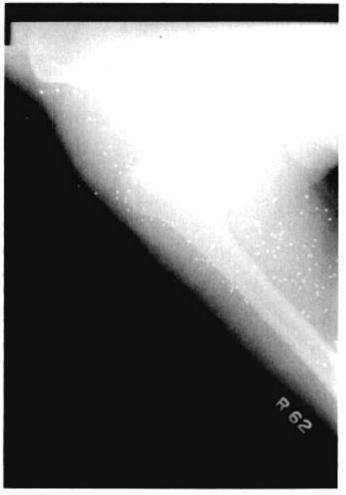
Full load of No. 6 shot in right thigh. Using the formula provided the effective range for this wound was 12 meters. This would be 12 meters for a standard length shotgun or much closer for a "sawedoff" shotgun. This would make this wound a Type II, with a moderate amount of tissue damage and mortality rate of approximately 15–20%. The actual length of barrel used is not important as the effective range is known in this case. The effective range may be calculated in three ways for this wound. First, the full load produced a wound with a diameter of 14 inches which may also be measured by the pellet spread on X-ray. Assuming a spread of approximately 1 inch per meter from 2 to 100 meters range, this would indicate that the weapon-victim range was approximately 12 meters. Second, the effective range can be calculated after measuring the distance between pellets. The shot size is measured at .11 inches in diameter which is #6 shot (see Table II) and each 1½-ounce load would contain approximately 350 pellets. The average measured distance between pellets using either a measurement of wounds in the skin or by X-ray is 0.3 inches. Thus
